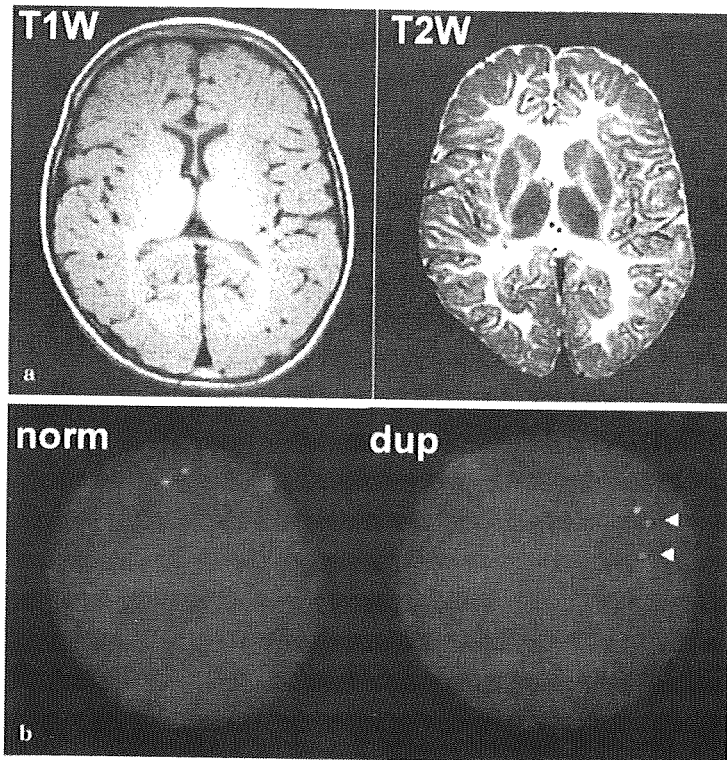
特徴的な PMD の MRI 画像と FISH 法による *PLP1* 重複の同定
